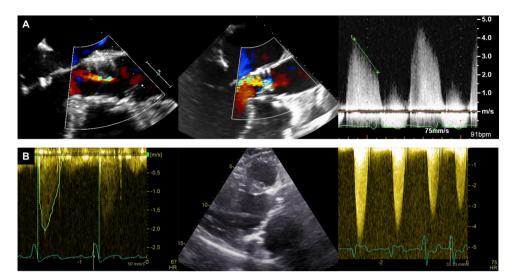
Structural valve deterioration after transcatheter aortic valve replacement showing severe transvalvular aortic regurgitation (*panel A*) or severe prosthetic valve stenosis (*panel B*). *Panel A* shows a patient receiving a balloon-expandable valve with periprocedural transoesophageal echocardiography demonstrating mild paravalvular regurgitation on color Doppler (left panel). After 4 years follow-up, transoesophageal echocardiography showed severe transvalvular aortic regurgitation on the color Doppler image (middle panel), confirmed by continuous wave Doppler recordings with steep downsloping of the regurgitant flow (right panel). *Panel B* shows a patient receiving a balloon-expandable valve with periprocedural transoesophageal echocardiography demonstrating low transprosthetic gradients (left panel). After 6 years of follow-up, transthoracic echocardiography showed thickened and calcified prosthetic valve leaflets on the long-axis view (middle panel). Increased transprosthetic gradients were observed on continuous wave Doppler (right panel), confirming the presence of severe prosthetic valve stenosis. Both patients underwent a valve-in-valve implantation.
